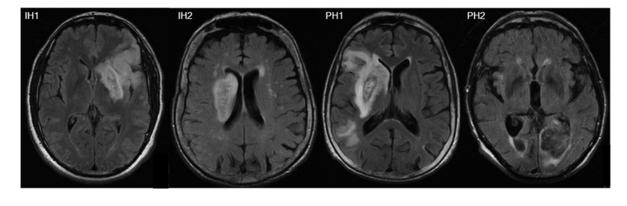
Figure I Types of HT in MRI-FLAIR according to ECASS criteria
